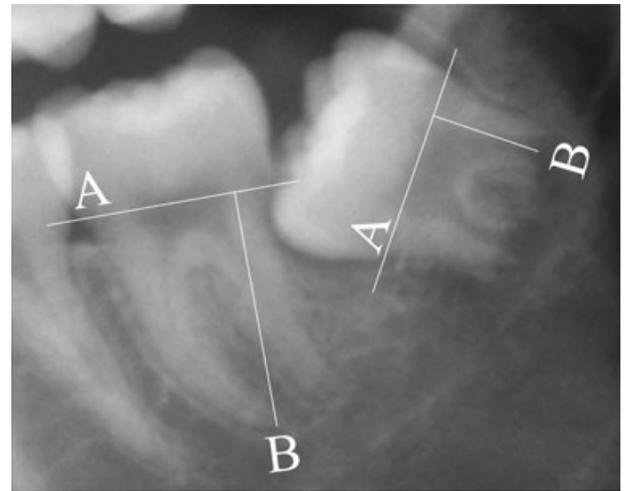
Section of orthopantomogram imported in Adobe® Photoshop® showing a developing third molar for scoring. Two lines are drawn, one between the mesial and distal enamel–cement junction (A) and one from the middle of the root end perpendicular to the first line (B). Next the ratio between root length of third and second molar is calculated so as to obtain an idea of third molar root length developed so far. Root length third molar is 3.80. Root length second molar is 7.39. Ratio is 0.51. Developmental score is 6 (root ½ calcified).
